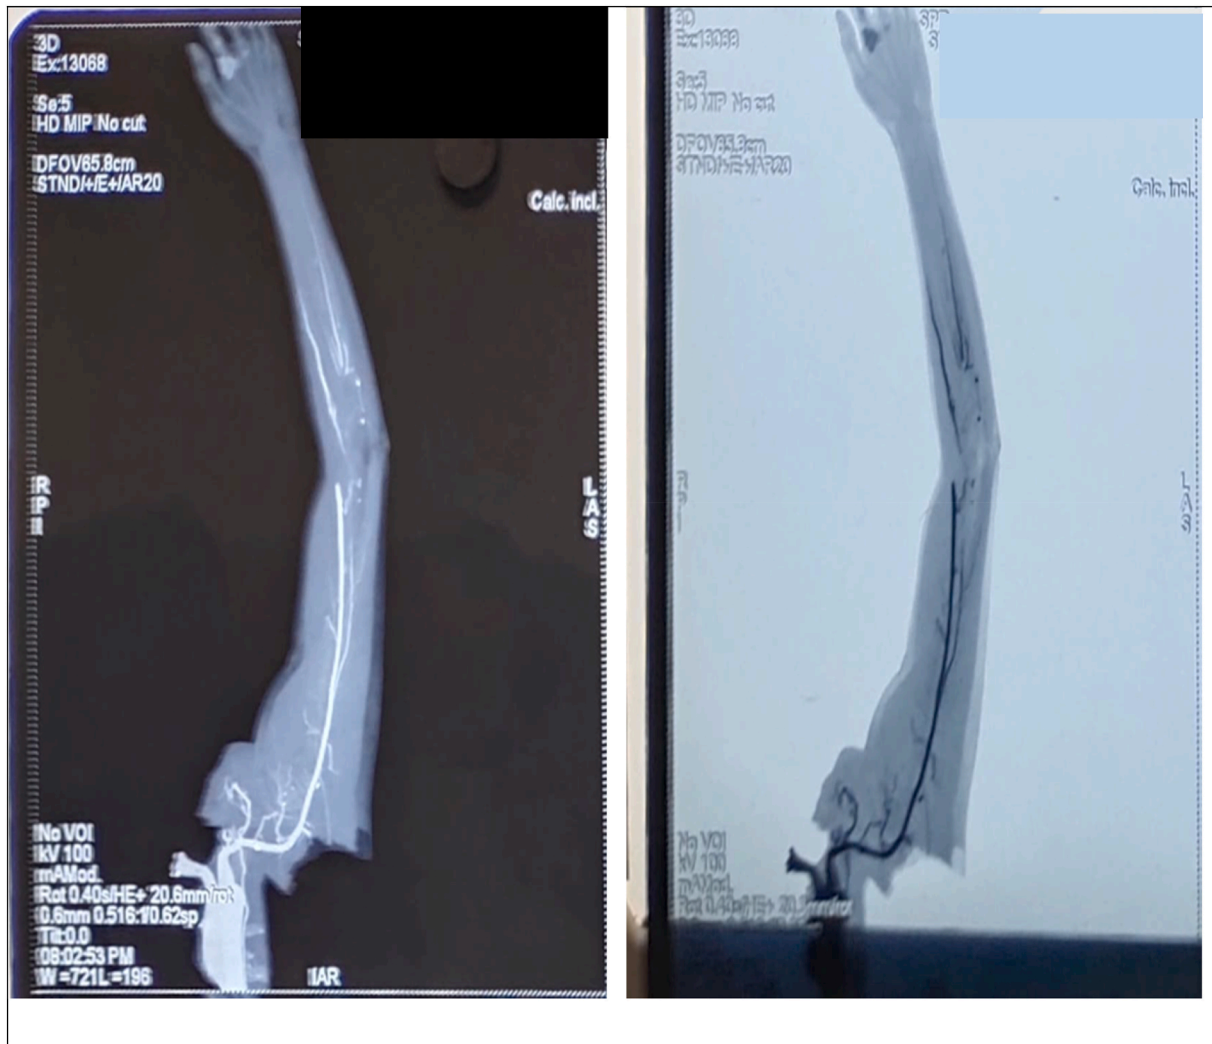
CT Angiography of left upper limb dated 19/11/21
